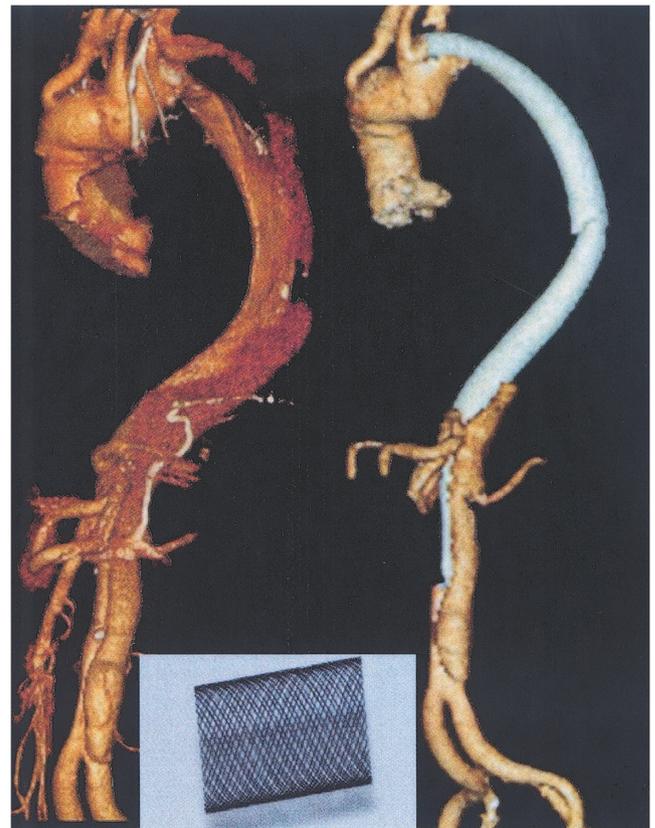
Left: preoperative CT-scan reconstruction. Right: postoperative month 3 CT-scan reconstruction: the thoracic false lumen is no longer patent. Bottom: multilayer stent photograph. CT, Computed tomography.
